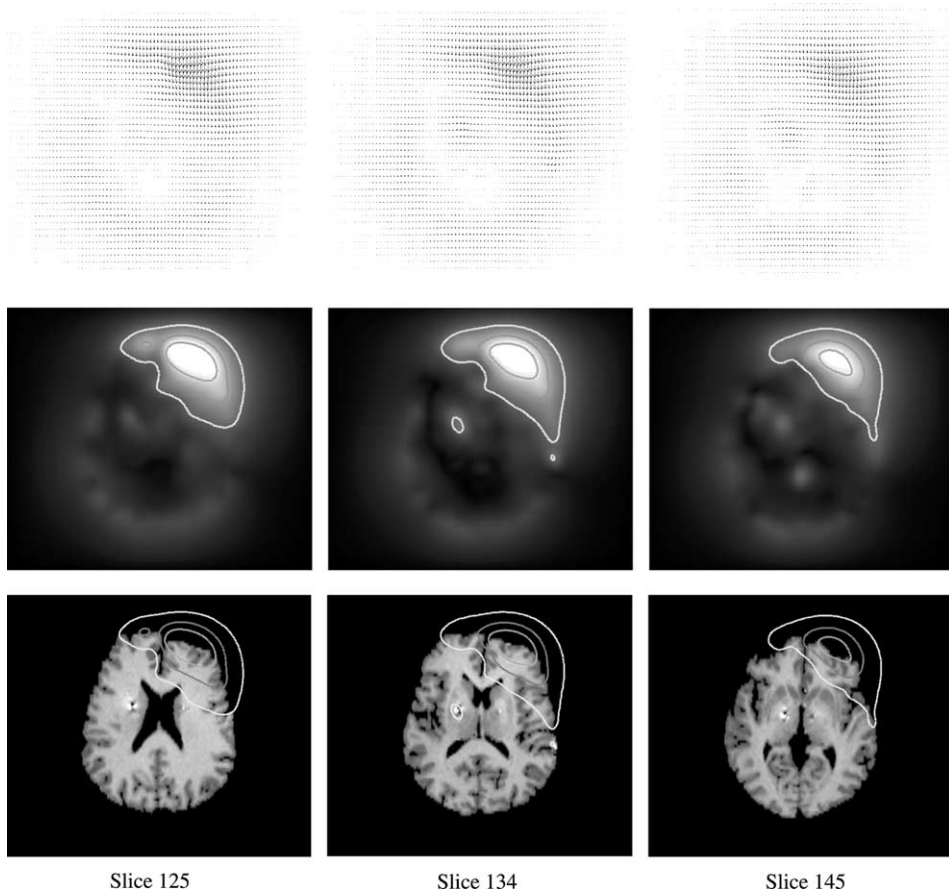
Nonrigid registration of pre- and postoperative MR images of the same patient, starting from the rigidly registered images, after brain extraction. Columns correspond to three different axial slices. First row: deformation field; second row: norm of the deformation; third row: postoperative image. On the last two rows, isolines of the deformation norm (1, 2, and 3 mm) are superimposed on the images.
